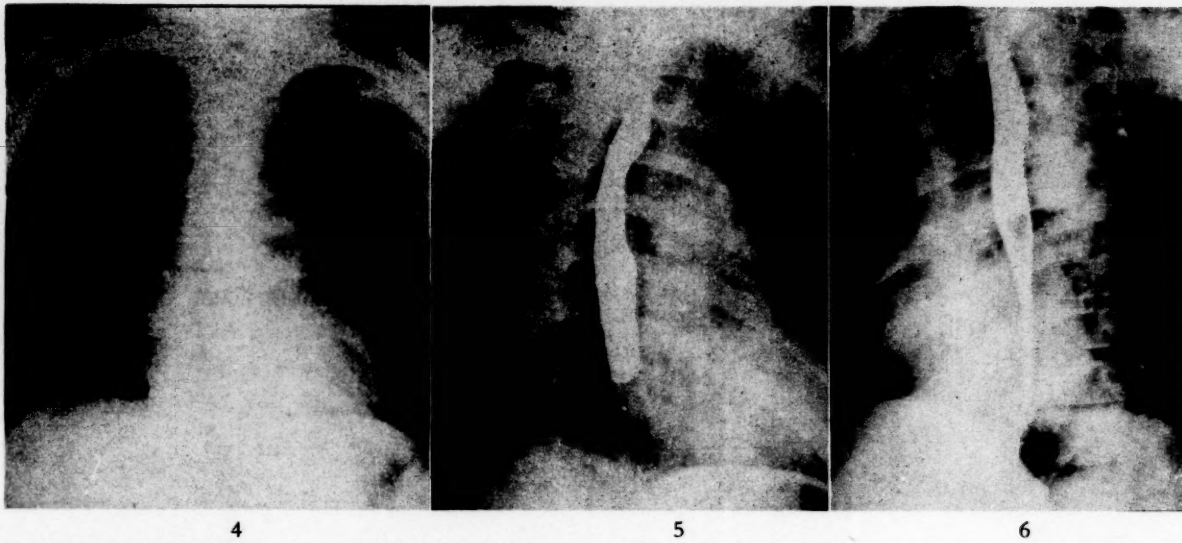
Roentgenogram of the patient's chest in Case 1, postero-anterior projection.
